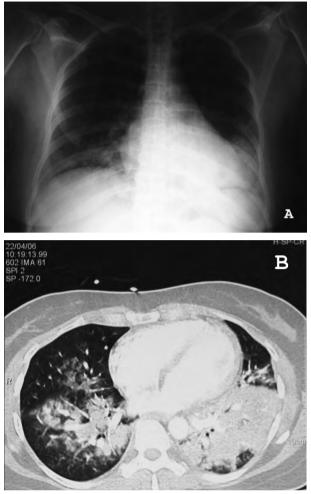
Radiography (A) on admission and CT (B) on admission of the first case.
